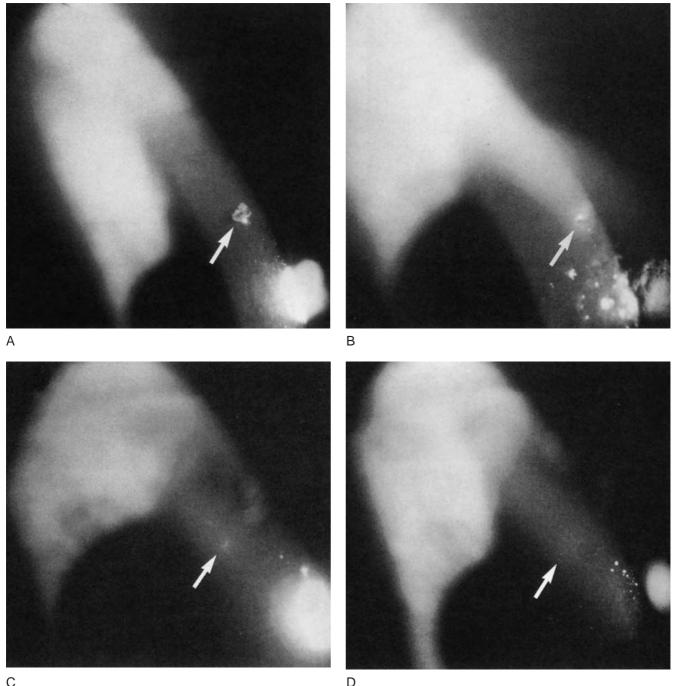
Corneal rust ring removal. Introduced tangentially to the cornea (*A*), the Alger brush is used to remove rust-containing epithelial cells gently (*B*). (From Casser L, Fingeret M, Woodcome HT. Corneal rust ring removal. In: Atlas of primary eyecare procedures, ed. 2. Norwalk, CT:Appleton & Lange, 1997: 170-173.)
